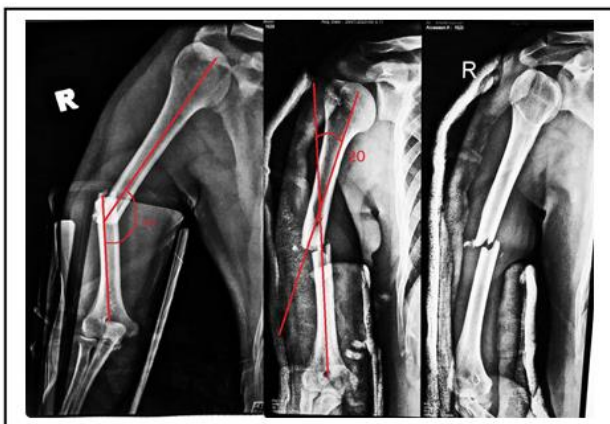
radiograph of right humerus pre and post reduction and splinting
